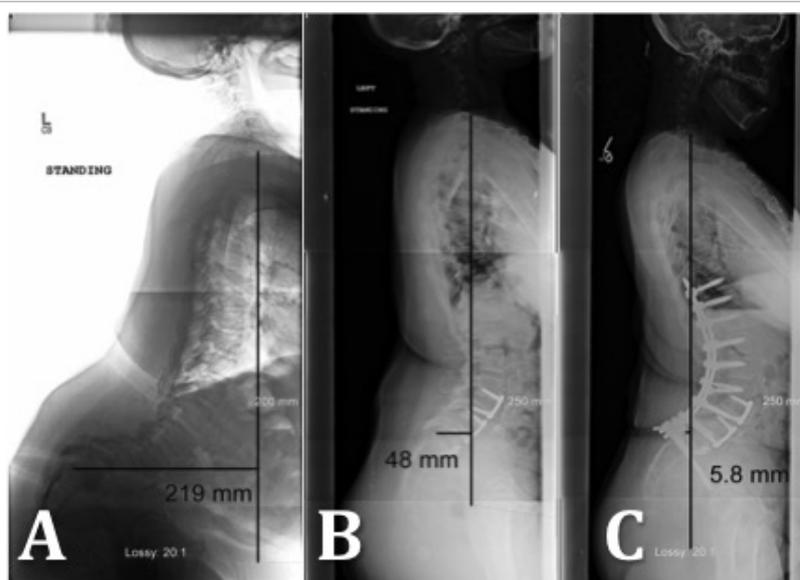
A) Preoperative standing x-ray of the spine demonstrates sagittal vertical axis (SVA) of 219 mm. B) After a three-level ALIF at L3/4, L4/5 and L5/S1, SVA decreased from 219 mm to 48 mm. C) 36-inch standing radiograph taken at 10-month follow-up. She underwent stage two posterior instrumented fusion from T10 to the pelvis with a near complete resolution of her sagittal deformity and a SVA reduced to 5.8 mm.
